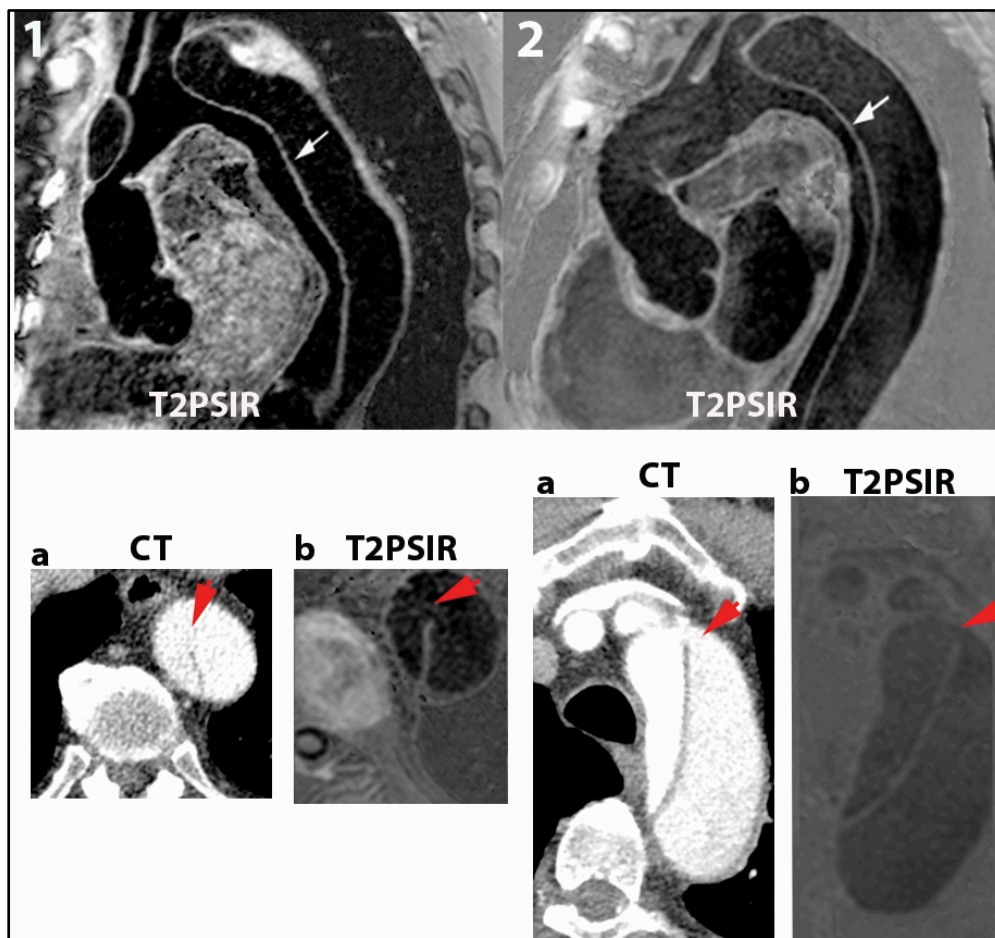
SAGITTAL SECTION IMAGES SHOWING  $T_2$ PSIR SEQUENCES PERFORMED IN TWO PATIENTS WITH CHRONIC TBAD. THE WHITE ARROWS SHOW THE POSITION OF THE INTIMAL FLAP, WHICH IS CLEARLY VISUALIZED. CROSS-SECTIONS OF EACH PATIENT'S A) CT SCAN AND B) MRI ( $T_2$ PSIR) SEQUENCE ARE SHOWN BELOW THE SAGITTAL IMAGES. THE RED ARROWS INDICATE THE POSITION OF THE INTIMAL TEAR IN EACH OF THE IMAGING MODALITIES.
